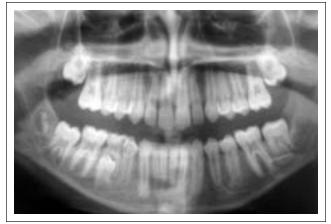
Panoramic radiograph 40 months after surgery. There are no signs of clinical and radiographic recurrence. The permanent germs on the left side of the mandible were preserved and are erupted. Only the third molar germ was excised.
